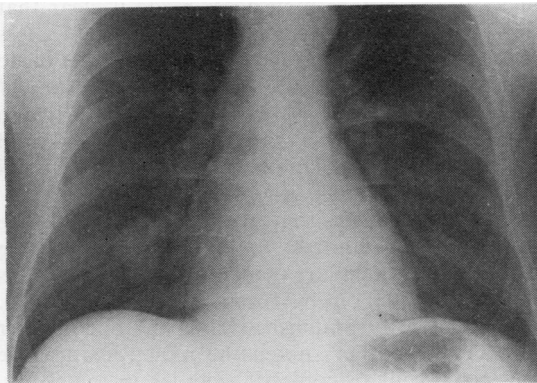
Chest radiograph showing a lesion in the right lung.
